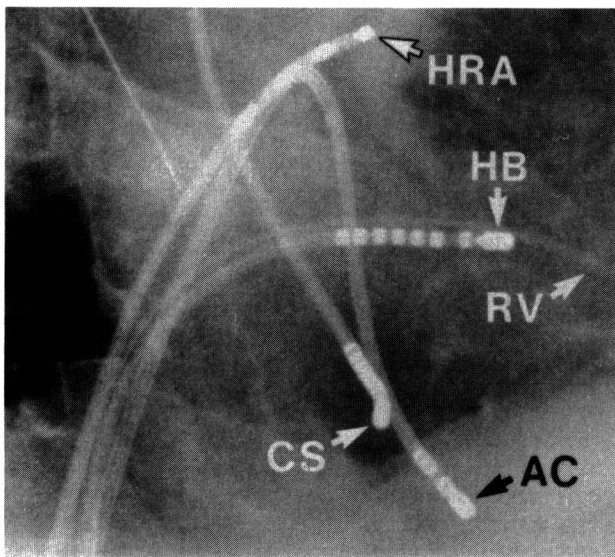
This page and facing page. Radiographic views of successful ablation sites. Radiograms are obtained from three different patients. For each patient, the right anterior oblique view is shown on the left and the left anterior oblique view is shown on the right. The intracardiac catheters are positioned in the high right atrium (HRA), His bundle region (HB), right ventricular apex (RV), and coronary sinus (CS). The ablation catheter (AC) is shown at the successful sites, which are the posteroseptal aspect of the tricuspid annulus (facing page, top), the coronary sinus ostium (facing page, bottom), and the inferomedial aspect of the right atrium posterior to the coronary sinus ostium (above). Note that the AC is introduced to the targeted areas using a femoral vein (facing page, top; above) or right internal jugular vein (facing page, bottom).
